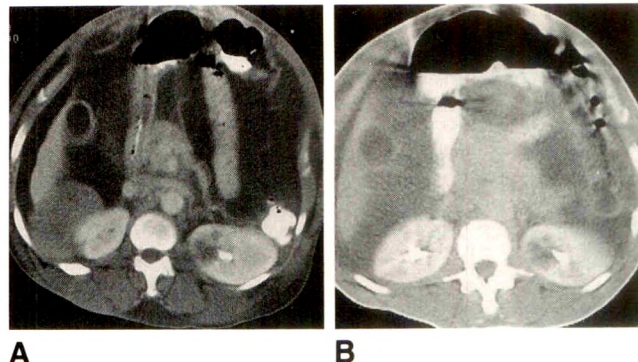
A and B, Contrast-enhanced CT scans show spontaneous disappearance of abdominal tumor. Initial scan (A) shows mass in Morison pouch; mass has no significant enhancement. Scan (B) obtained 5 days after A, before planned biopsy and after "laying on of hands," shows mass is no longer present.
